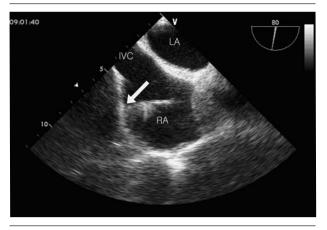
Overshoot P waves appeared when the central venous catheter tip (arrow) was contacting or in close proximity to the wall of the right atrium (RA) on transesophageal echocardiography. IVC = inferior vena cava, LA = left atrium.
